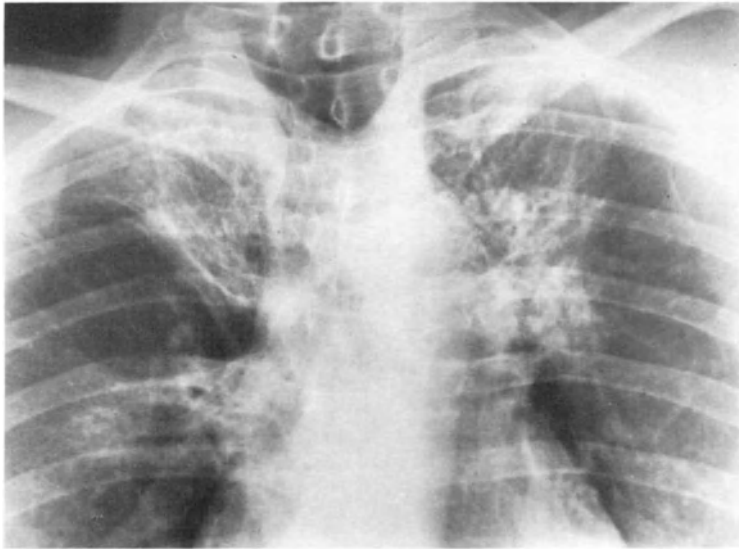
Pulmonary mediastinal fibrosis after successful X-ray therapy
